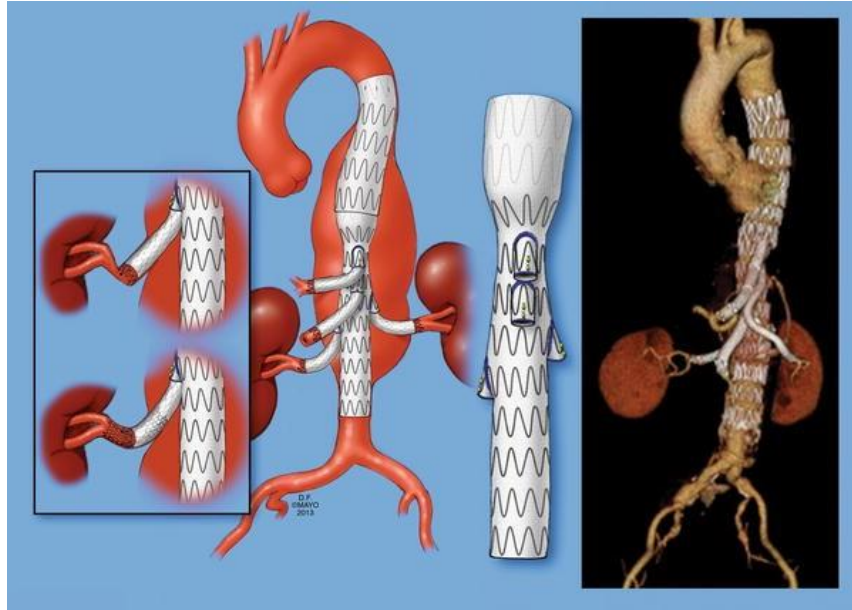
Endovascular repair of a type II thoracoabdominal aortic aneurysm using a physician-modified branched stent graft with a post-operative computed tomography angiography demonstrating exclusion of the aneurysm and patency of the visceral branches. Note in the inset the use of bare-metal stents to avoid kink in the renal artery after deployment of the covered stent. Image from Mendes, B.C., Oderich, G.S., Correa, M.P. et al. Endovascular Repair of Complex Aortic Pathology. *Curr Surg Rep* 1, 67–77 (2013). <https://doi.org/10.1007/s40137-013-0019-9>.
